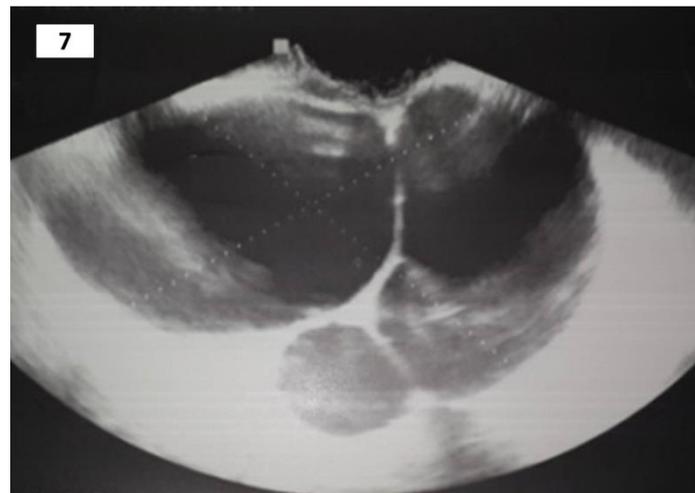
Ultrasound appearance of a mucinous cystadenoma (definitive pathologic diagnosis). The cyst was located on left ovary in a postmenopausal (fifty-three years old) woman hysterectomized 12 years ago without oophorectomy. It may be difficult to distinguish it from the “spider in web” appearance.
